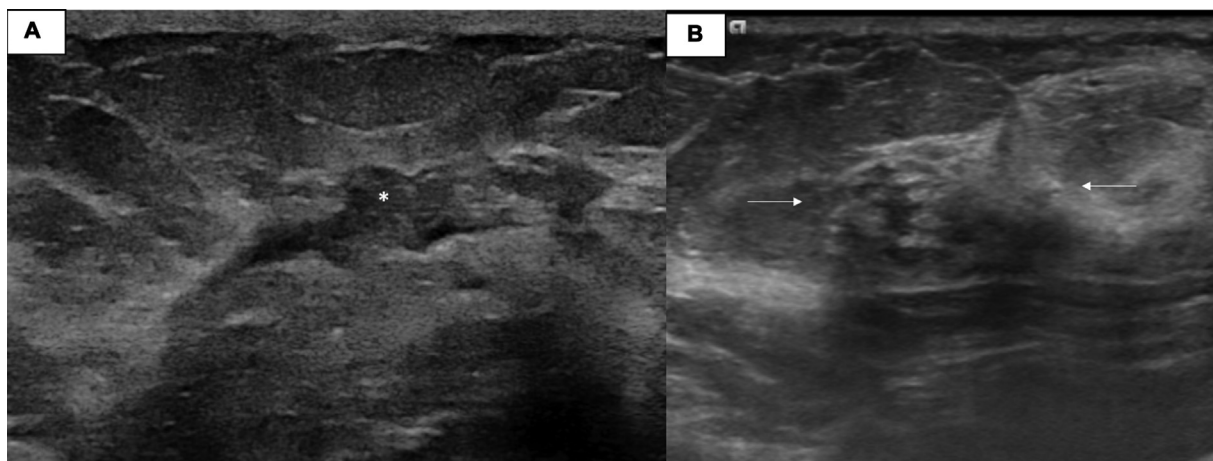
Nonmass lesions according to echogenicity on ultrasound. (A) Hypoechoic pattern—Ill-defined nonmass lesion (asterisk) is seen that is hypoechoic as compared to surrounding parenchyma seen in a female postchemotherapy; (B) Mixed echogenicity nonmass finding (arrows) seen in patient with architectural distortion on surveillance mammogram.
